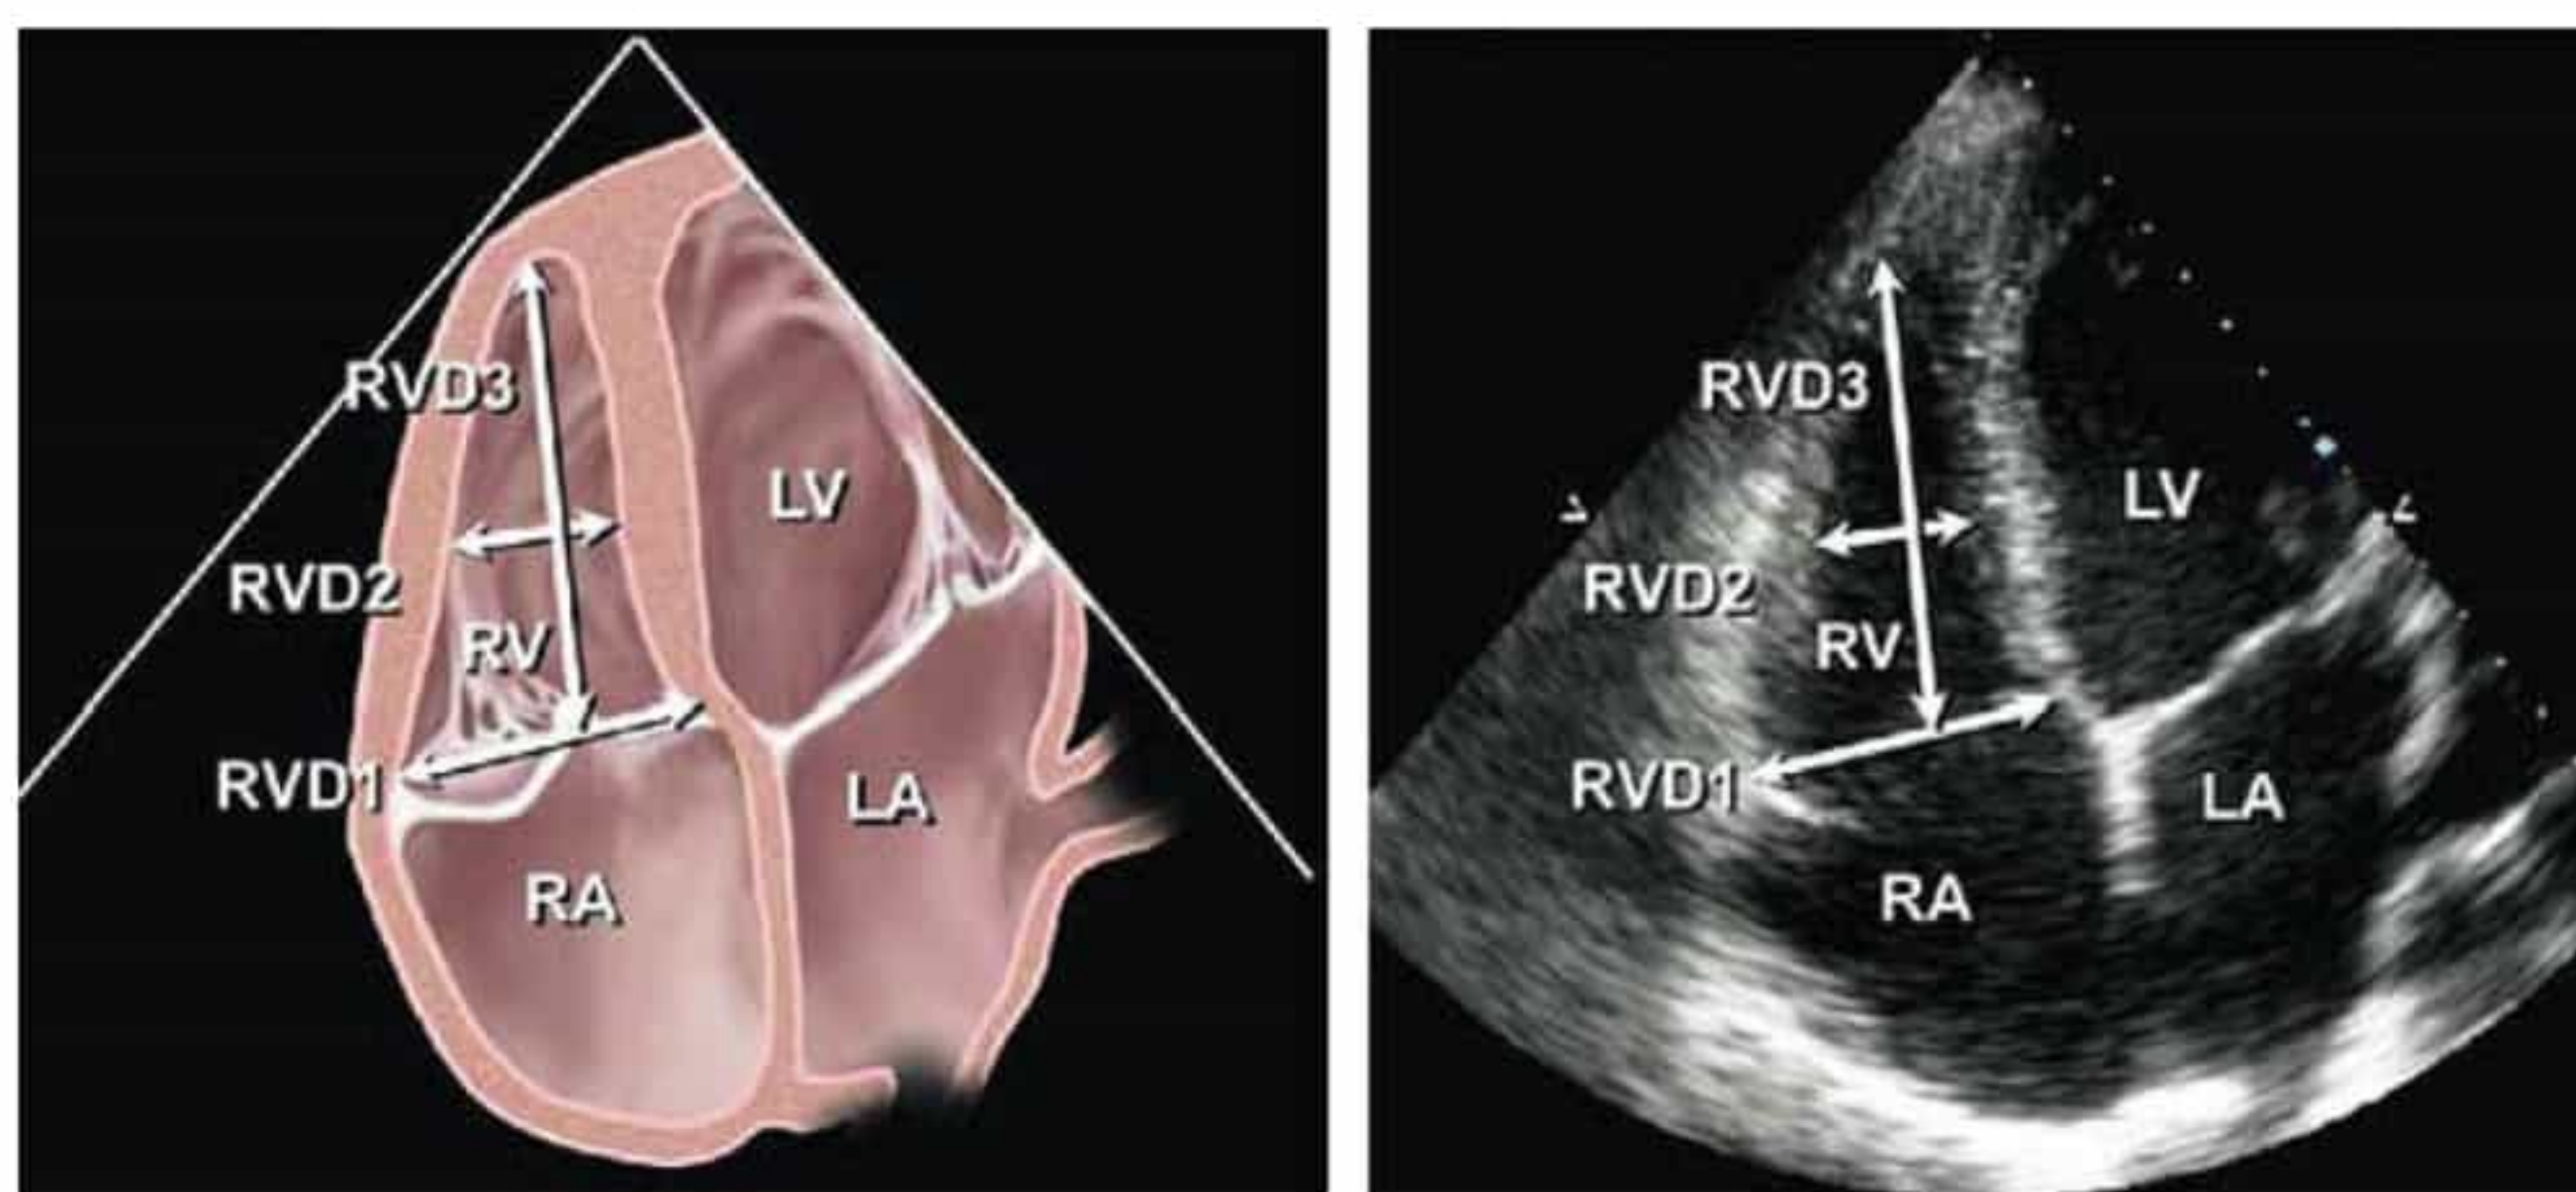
Measured in the apical 4-chamber view at end-diastole. The maximum diameter of the RV should be obtained without fore-shortening. RV diameter >42 mm at base (RVD1) or >35 mm at mid-RV (RVD2) and longitudinal RV dimension >86 mm (RVD3) indicates RV dilatation.
